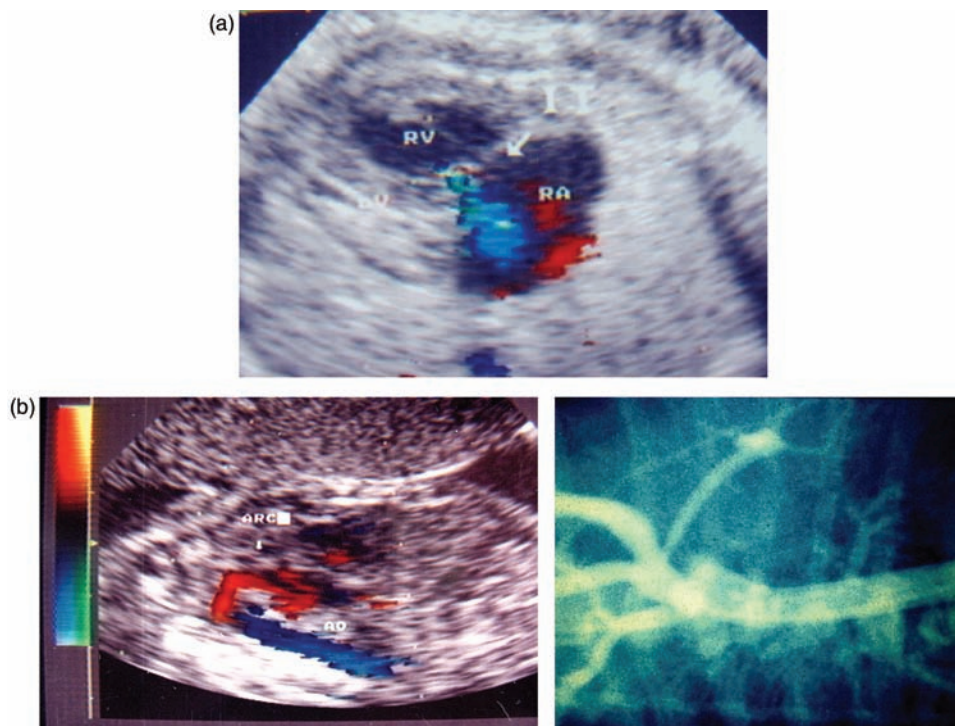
Hypoplastic left heart syndrome with mitral atresia and aortic atresia. (a) Single ventricular cavity corresponding to the right ventricle. Tricuspid regurgitation is seen. (b) Echocardiograph/angiogram to show the retrograde aortic arch opacification as no blood is ejected through the aortic valve.
